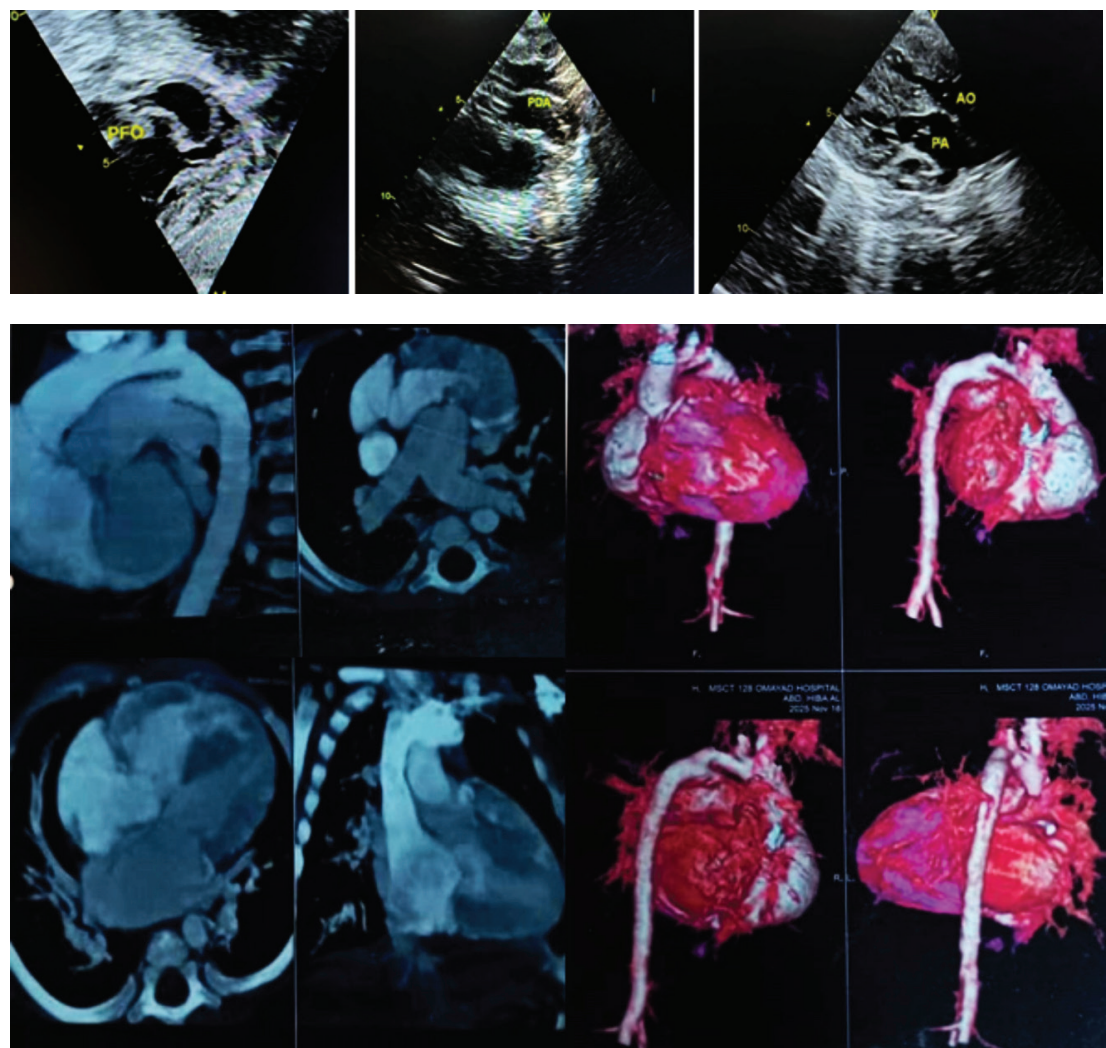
Transthoracic echocardiography demonstrated situs solitus, atrioventricular concordance, and ventriculo-arterial discordance consistent with parallel circulation D-TGA. Notably, the right ventricle was severely hypertrophic, with extreme thickening of the anterior wall, a large patent ductus arteriosus (4 × 5 mm), an inlet ventricular septal defect (6 × 9 mm), and a patent foramen ovale (4 × 5 mm).
